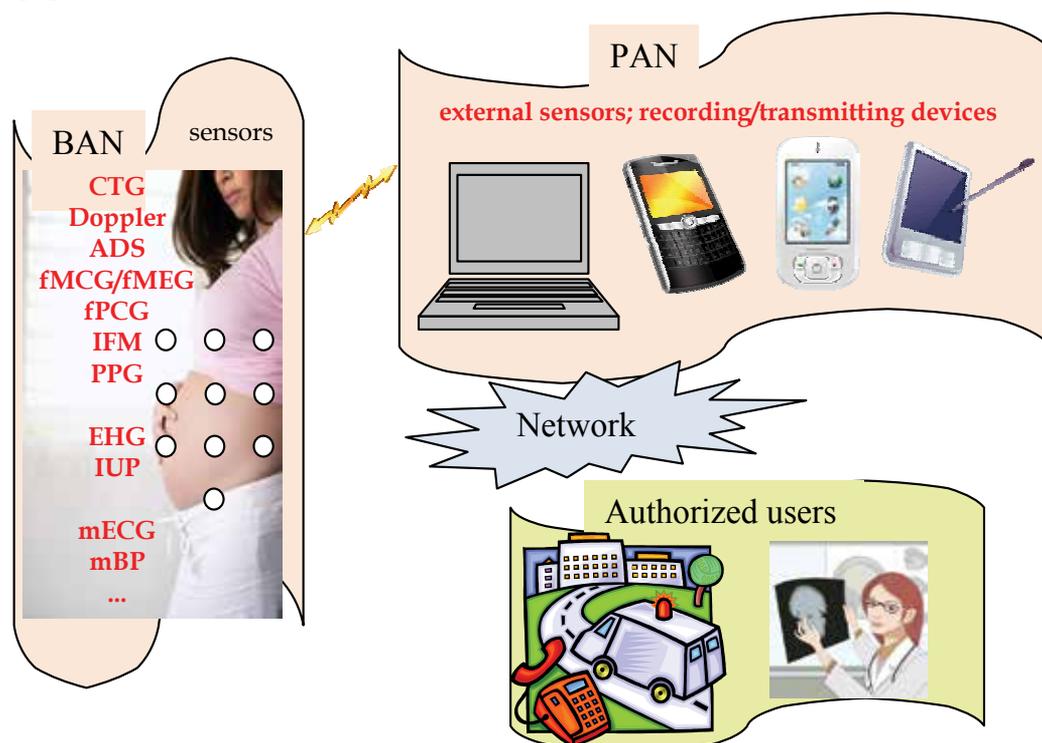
A simple fetal telemedicine application scenario. Several biosignals were recorded continuously from the pregnant woman through the BAN (CTG, Doppler, ADS, fMCG/fMEG, fPCG, IFM, PPG, EHG, IUP, mECG, mBP) and monitored. They are transmitted to the PAN and further integrated into the prenatal telemedicine system to be available to authorized users.
